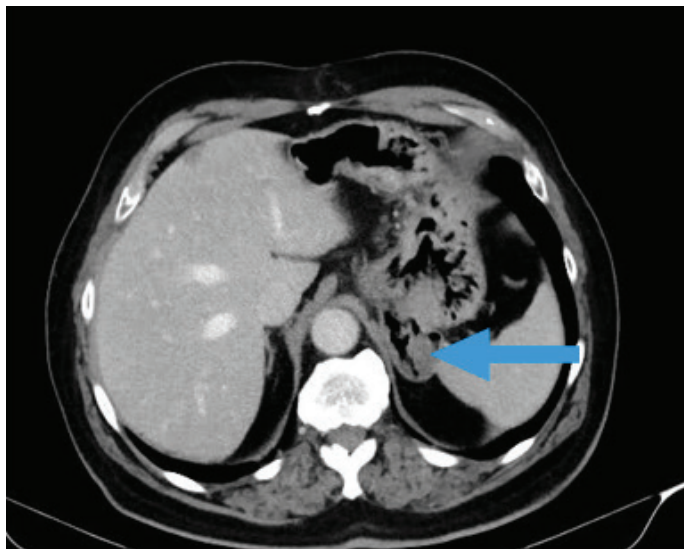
A well-defined sacular collection projected from the gastric fundus (blue arrow), Axial view of Computer Tomography (CT) abdomen showing gastric diverticulum.
